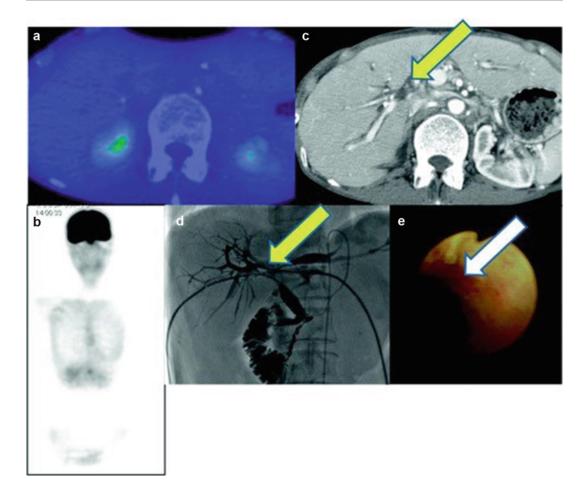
Pretherapeutic Klatskin tumor. PET/CT does not show abnormal [¹⁸F]FDG accumulation (a, b). Contrastenhanced CT and cholangiography shows multiple filling defects (c, d; *yellow arrows*) because of tumor in hilum.
